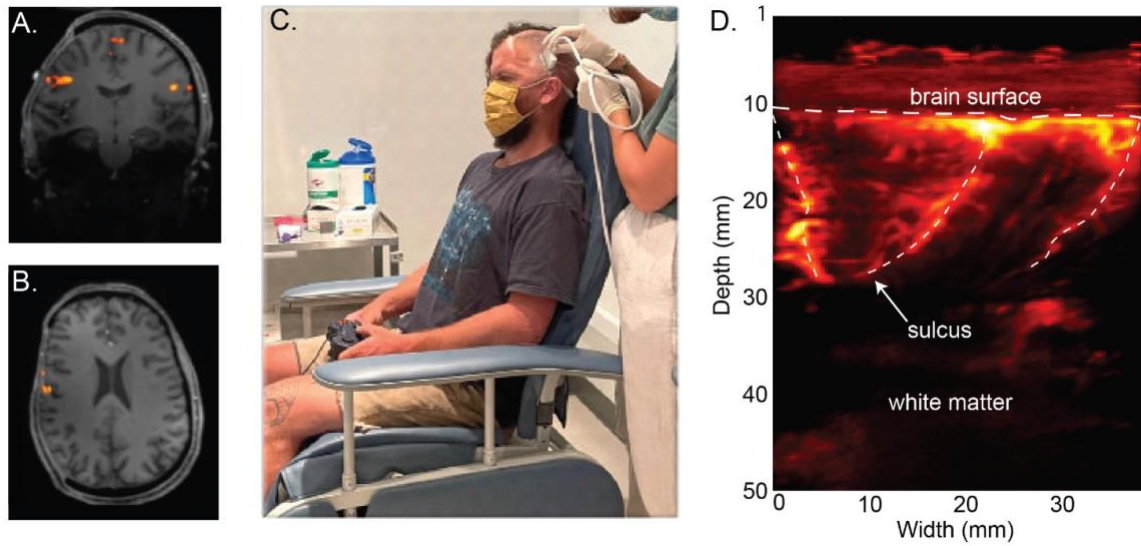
Ultrasound enables vascular imaging through intact scalp after craniectomy.
